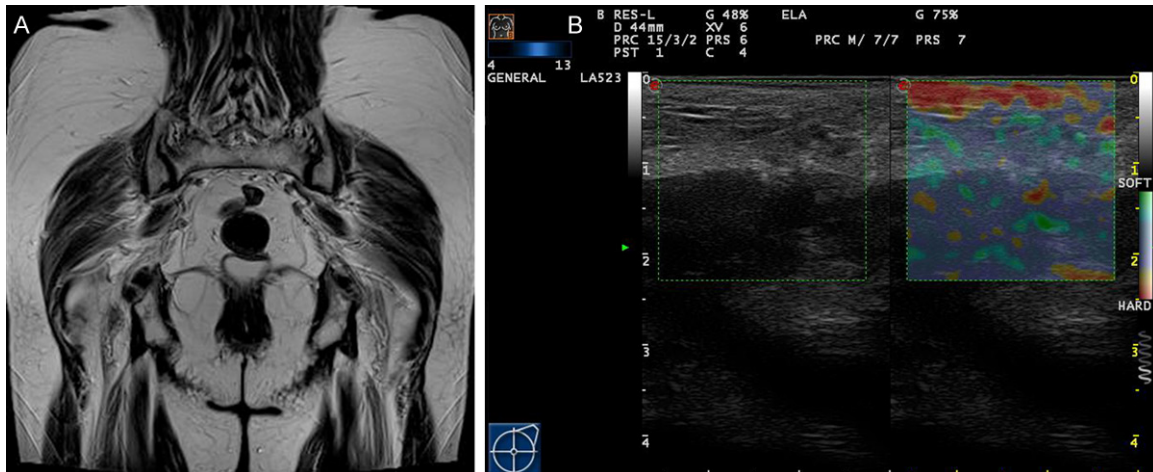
Case 1. A patient of levator ani with no defect detected by MRI (A). ES showed predominantly purple, green or yellow with less than 10% displaying red, scored as ES1 (B).
